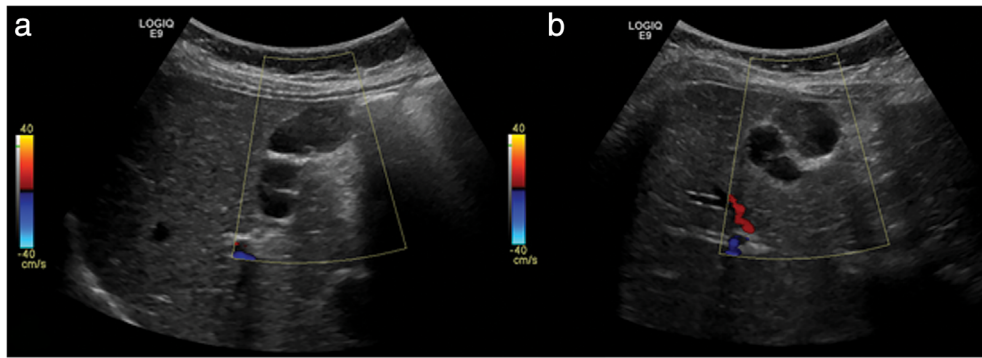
(a and b) Abdomen ultrasound shows multiple septations in the gallbladder in two views.
